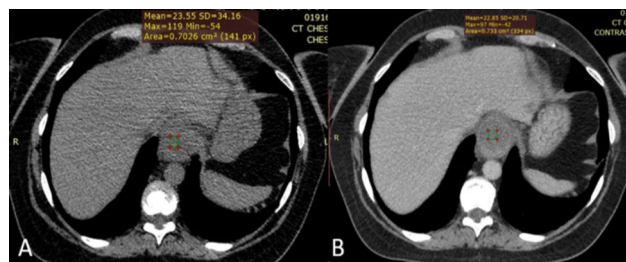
Non-contrast(A) and contrast-enhanced (B)CT. Collection located in the wall of the stomach, that does not change its density
